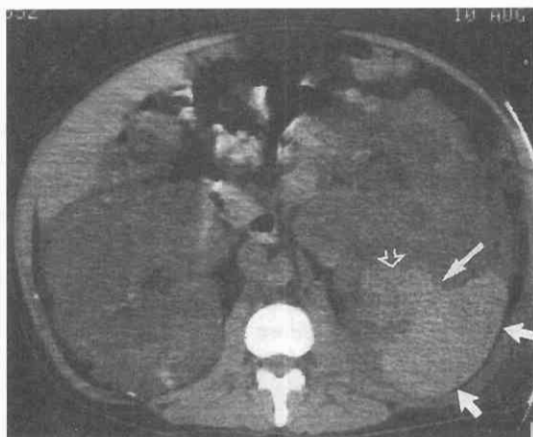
Autosomal dominant polycystic kidney disease with perinephric hemorrhage. Unenhanced CT scan reveals bilateral nephromegaly and multiple cysts. A posterior perinephric hematoma (short arrows) causes anterior displacement of the left kidney. A ruptured hemorrhagic cyst (open arrow) communicates (long arrow) with the hematoma. (From Levine E, Grantham JJ: Perinephric hemorrhage in autosomal dominant polycystic kidney disease: CT and MR findings. *J Comput Assist Tomogr* 11: 108-111, 1987.)
